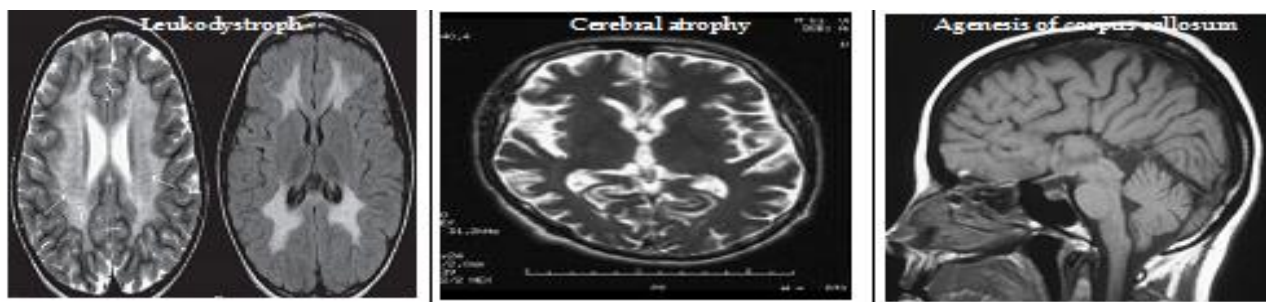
Showing commonly found MRI findings.
